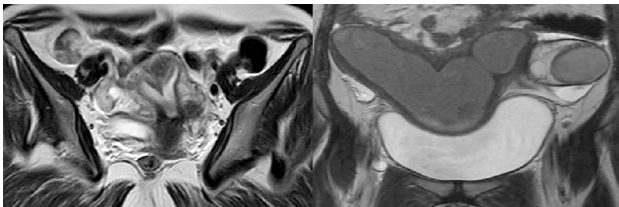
MRI T2 weighted Coronal Images: Two separate uterine horns with endometrial cavities are noted representing Bicornuate uterus.
